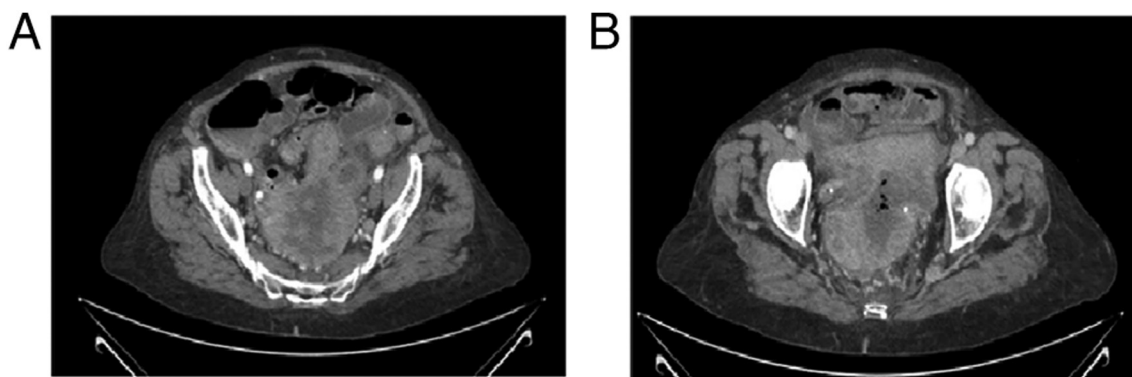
Posterior computed tomography scan revealing the worsening clinical condition of the patient 4 days later. (A and B) Pelvic mass with a wide necrotic mass in two different CT pelvic levels.
